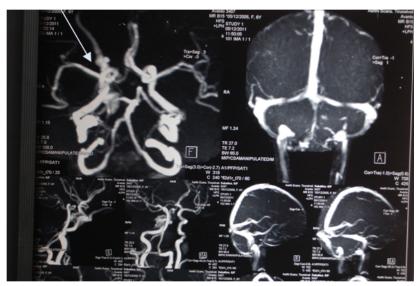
MRI showing carotid-cavernous fistula (arrow) and dilatation of right superior ophthalmic vein, with anterior venous drainage.
